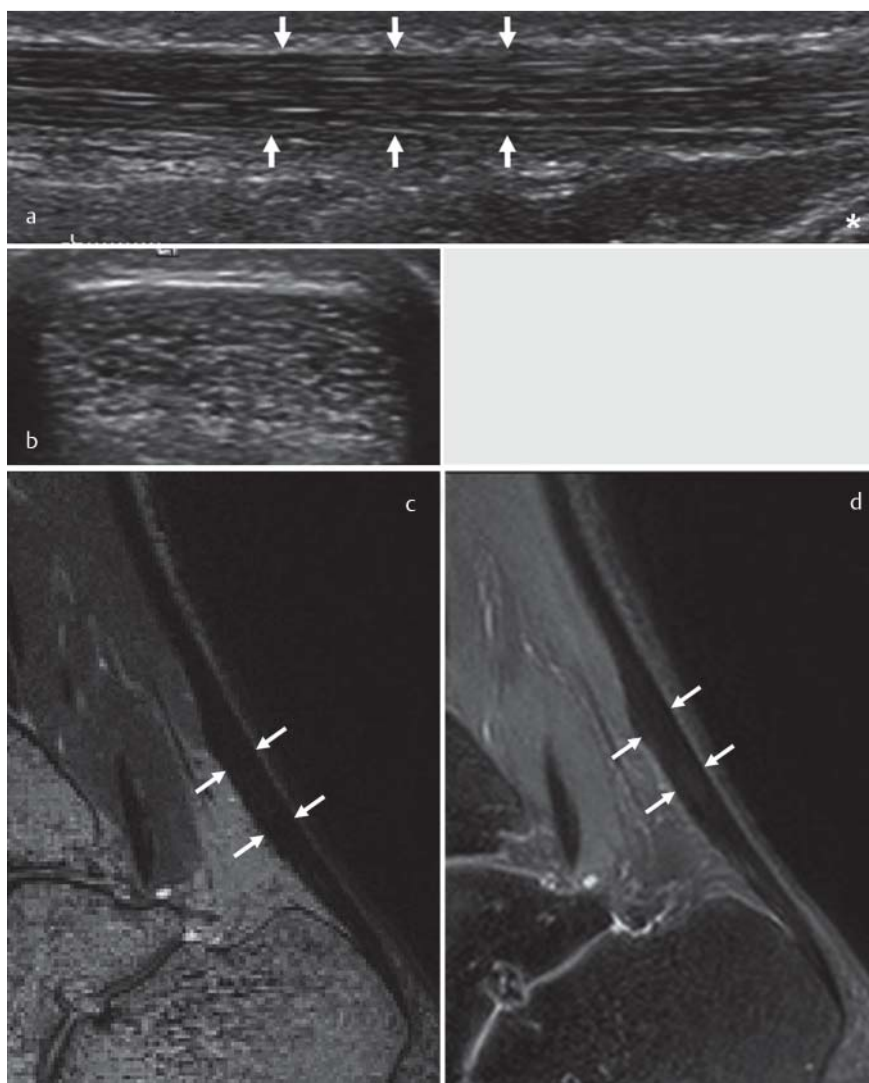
a The normal anatomy of the Achilles tendon in B-mode ultrasound images is presented in a, b. White arrows mark the boundaries of the Achilles tendon in the longitudinal view a while the proximal border of the calcaneal bone is marked by a white asterisk. The Achilles tendon shows a fibrillar homogenous echo pattern in longitudinal as well as in axial scans. c, d T2 weighted sagittal image without fat saturation and PD weighted image with fat saturation of the Achilles tendon at 3 T are presented. The healthy Achilles tendon appears dark. White arrows mark the boundaries of the Achilles tendon.
